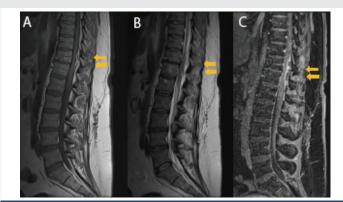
Spinal MRI showing an epidural MSSA abscess (Th11-Th12) in a patient with a resolved SARS-CoV-2 infection; T1-weighted acquisition (A) shows low signal images with high signal on T2-weighted image (B) and characterized by an intense contrast enhancement after Gadolinium administration (C).
